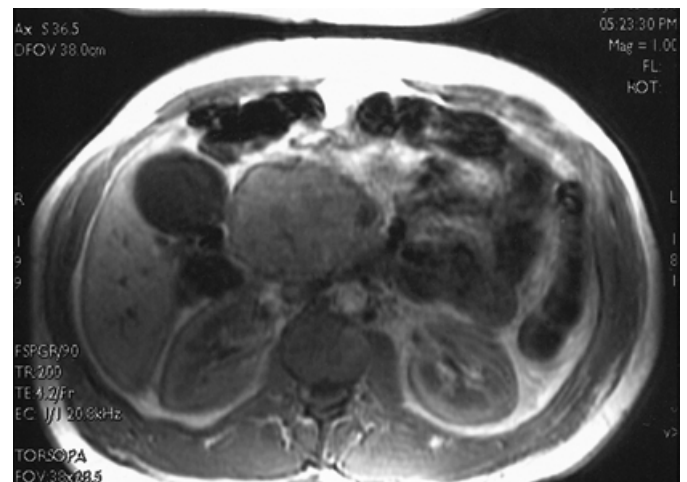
Magnetic resonance imaging scan. Coronal T1 image demonstrates the vasoactive intestinal polypeptide (VIP)-secreting tumour (8.5 cm) within the head and neck of the pancreas. There is displacement of the portal vein/superior mesenteric veins, but both remain patent.
